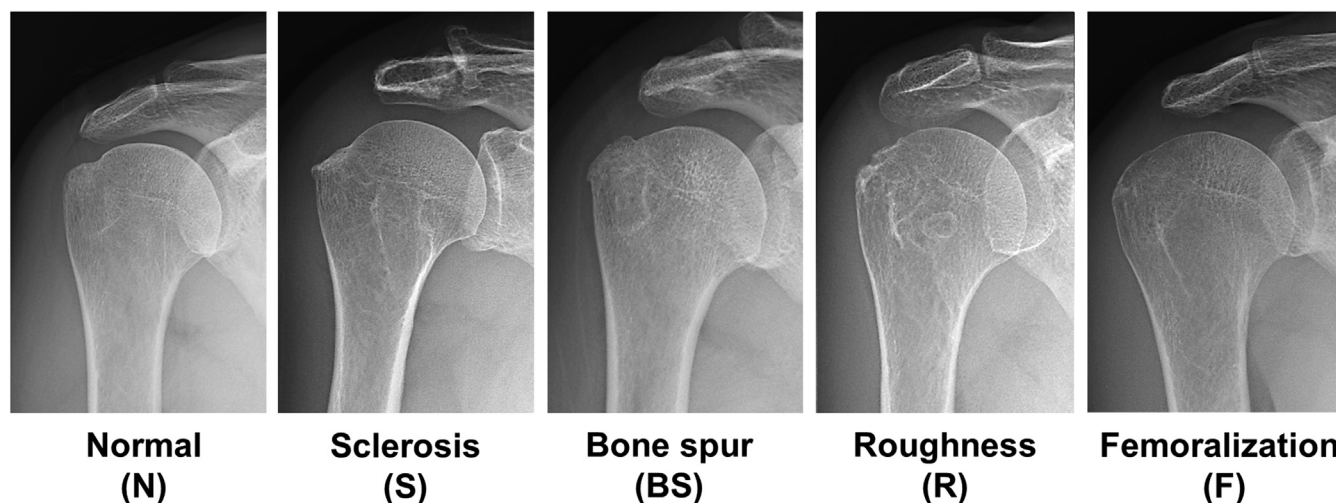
Classification of greater tuberosity morphology. The morphology is classified as “normal (N),” “sclerosis (S),” “bone spur (BS),” “roughness (R),” and “femoralization (F)” on anteroposterior radiographs with shoulder external rotation.
